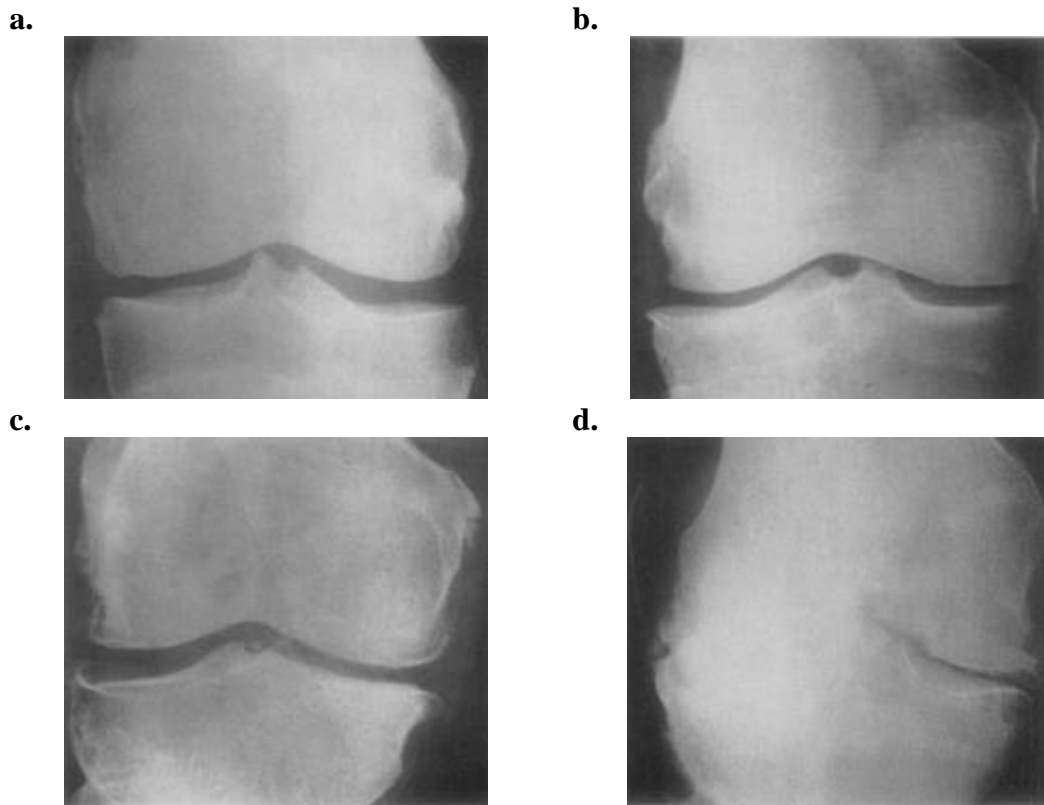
Radiograph of stages of knee OA as described by the Kellgren and Lawrence scale a. Grade I b. Grade II c. Grade III d. Grade IV (Kellgren and Lawrence, 1957)
